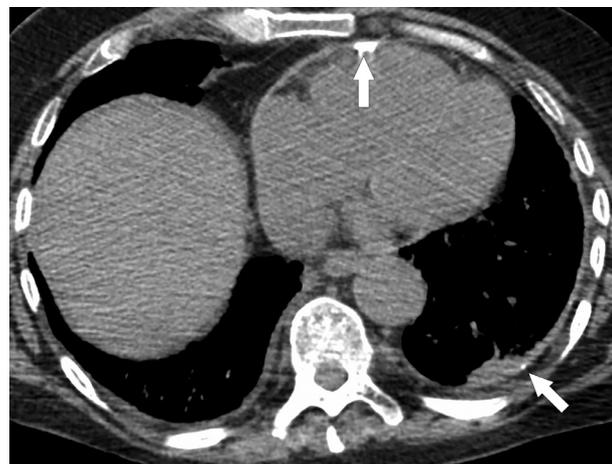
A 70-year-old male with longstanding serositis related to RA. Unenhanced CT image shows thickening and calcification (arrows) of the pericardium and left pleura. RA, rheumatoid arthritis.
